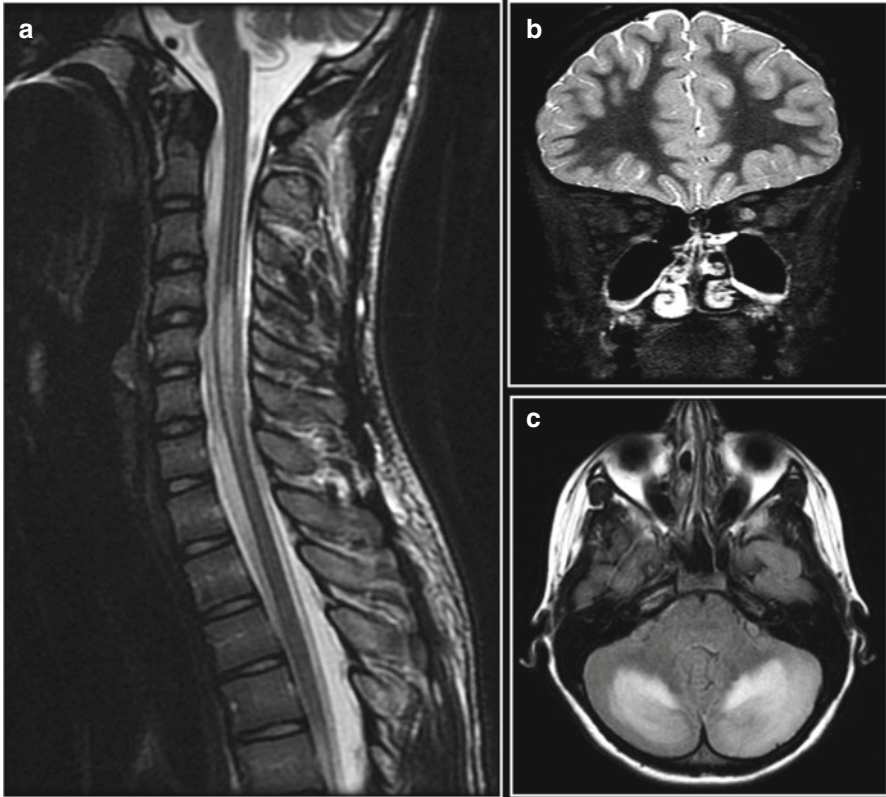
(a) Transverse myelitis: Sagittal T2-weighted MRI showing hyperintense signal in the cervical spinal cord of a patient who presented with bilateral leg weakness, sensory loss, and urinary retention. (b) Optic neuritis: Coronal T2-weighted MRI showing hyperintense signal and swelling of the left optic nerve in a patient who presented with unilateral vision loss. (c) Cerebellitis: Axial FLAIR MRI showing severe bilateral cerebellar hyperintensity and swelling with compression of the fourth ventricle in a patient who presented with headache, vomiting, and lethargy
